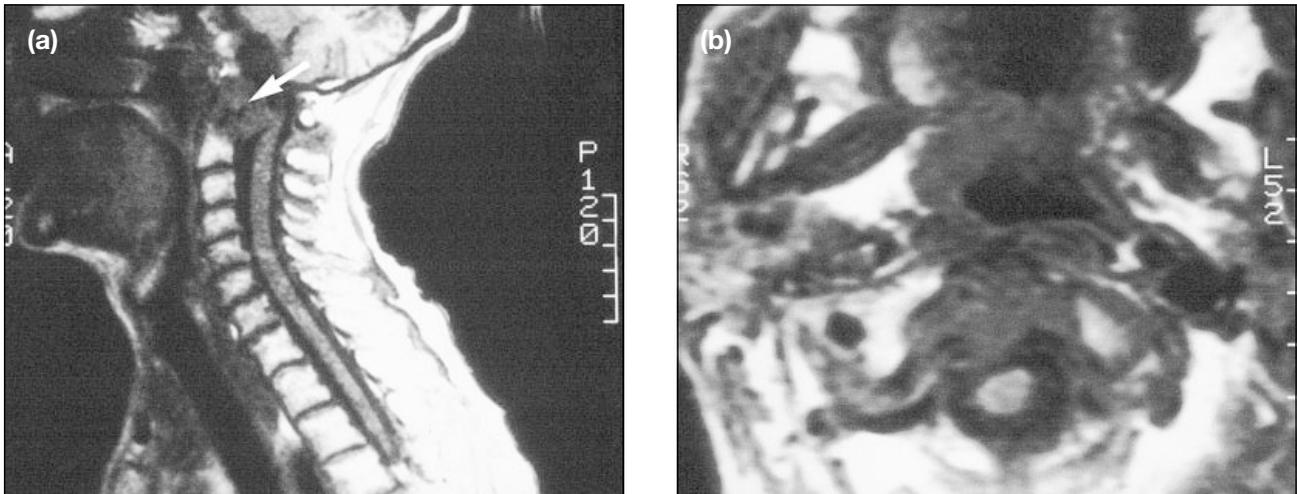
Patient with multiple joints affected by rheumatoid arthritis; T1-weighted images: (a) sagittal and (b) axial (TR 400 ms/TE 18 ms). In (a), an area of low signal intensity posterior to the odontoid peg can be appreciated, obliterating the CSF space anteriorly to the spinal cord (arrow). In (b), an anteriorly located nodule of pannus situated slightly to the right of midline can be seen protruding into the spinal canal, producing a slight mass effect on the spinal cord.
